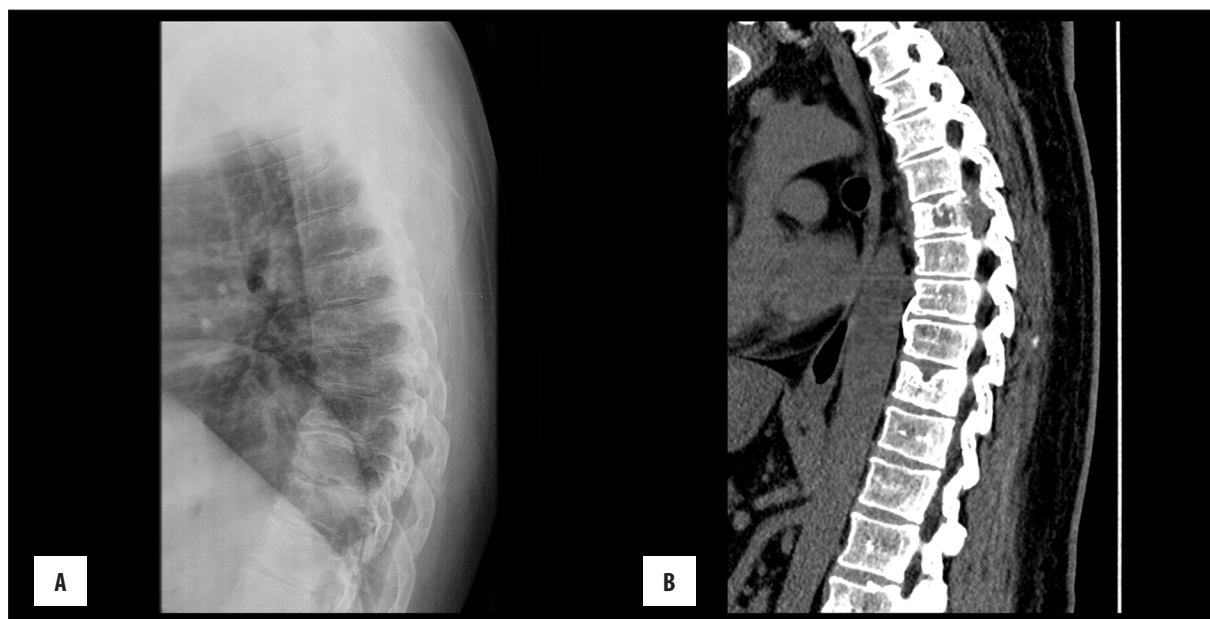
(A) X-ray and (B) CT sagittal reconstruction, vertebral lytic focus and spinal canal infiltration visible only on CT.
